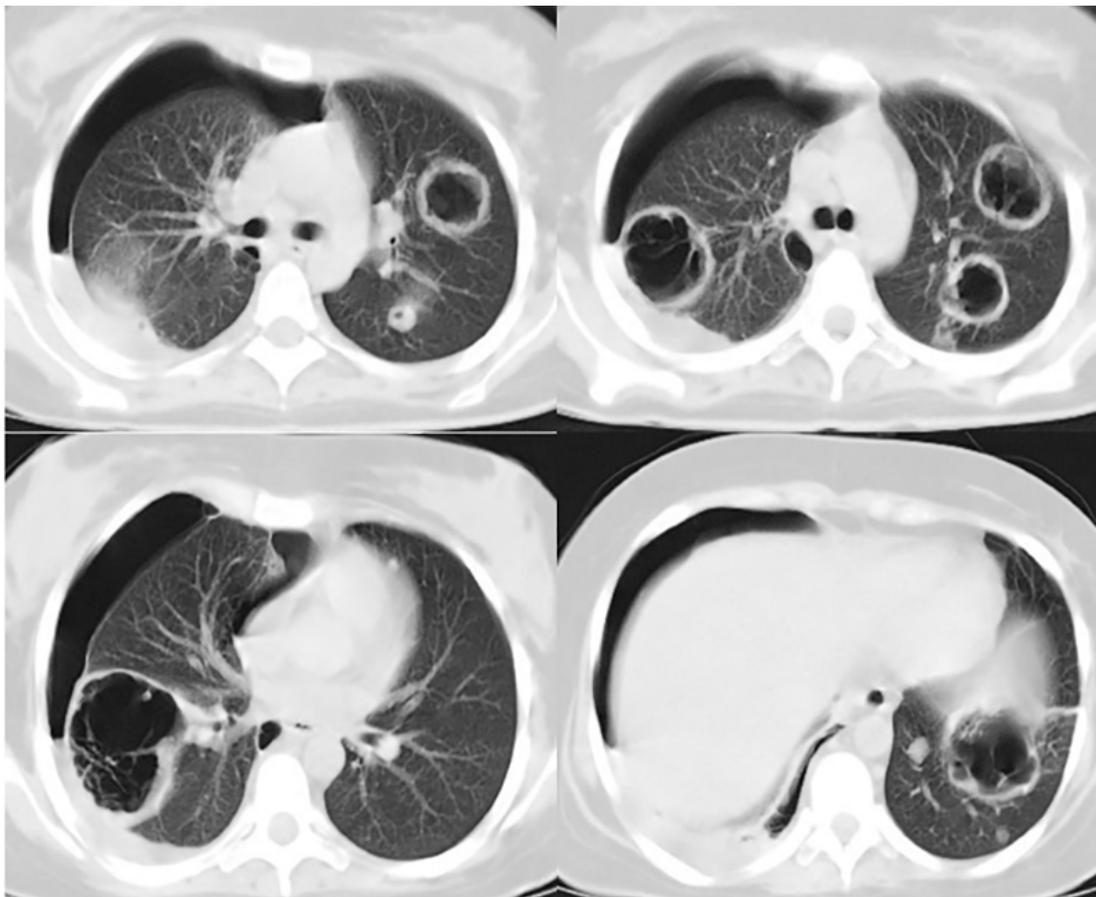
Spiral CT scan of the chest, showing several cavities and nodules in both lungs, some of which are cavitory. In addition, mild pleural effusion and pneumothorax were seen on the right side
